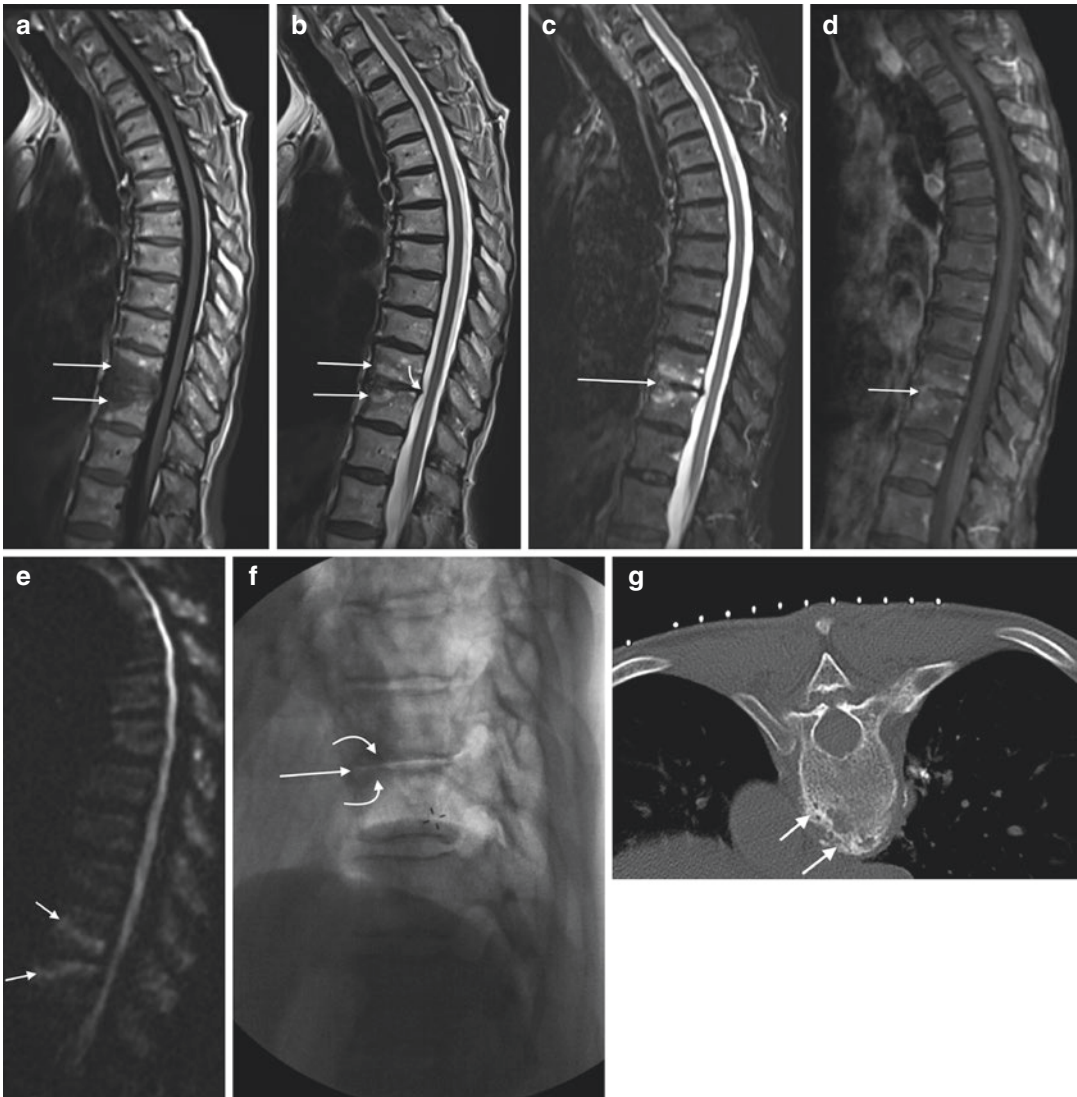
A 75-year-old female with severe mid-back pain. T1-weighted sagittal image (a) shows triangular areas of low signal intensity (arrows) at the T10–T11 level. These show mixed hypo- and hyperintensity (arrows) on the T2-weighted sequence (b) as well as a small disk protrusion (curved arrow). The inversion recovery sagittal image (c) shows focal hyperintensity within the anterior aspect of the disk (arrow). The fat-suppressed contrast-enhanced T1-weighted sagittal image (d) shows enhancement within the anterior disk and in the endplates (arrow). The patient was referred for a spine
